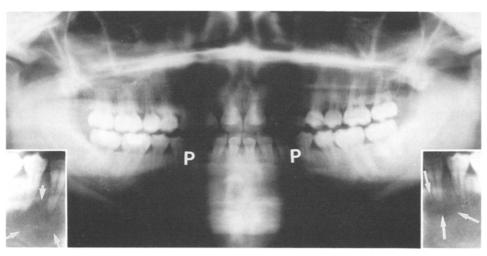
Orthopantomograph of the probands younger daughter (II-4, Fig. 3). The periapical regions of most teeth were unaffected. Insets show the mandibular premolar regions (P), where periapical radiolucencies (arrows) were present in relation to the first premolars (original radiograph was high contrast)
